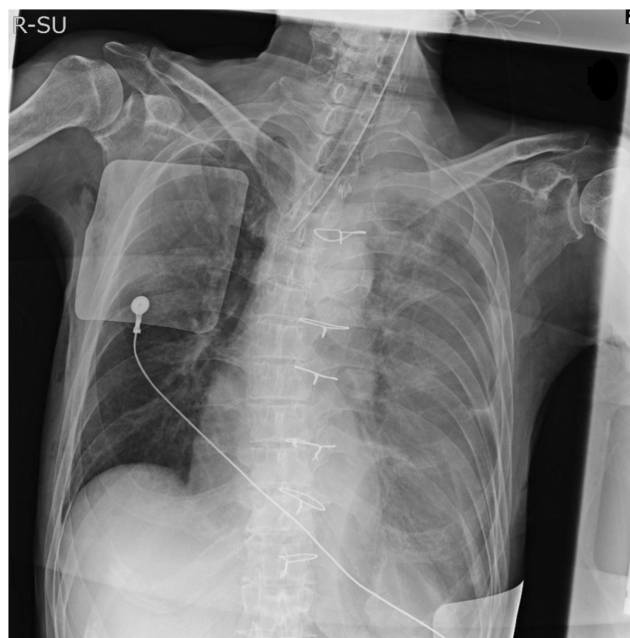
The chest radiographs show decreased permeability in the left lung and sternal wires.
